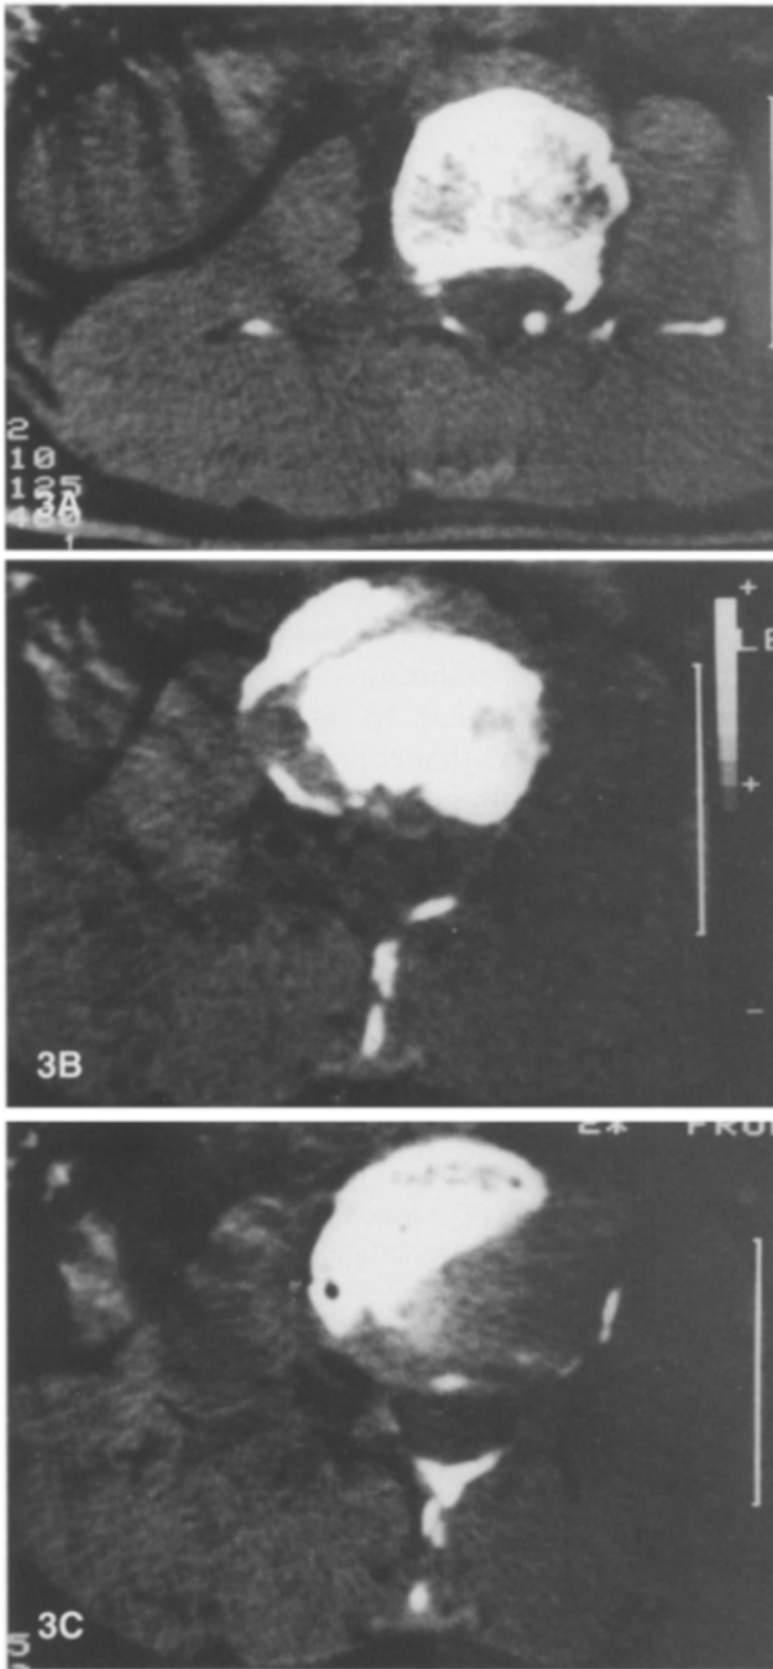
Sequential CT scans of the level L2 showing absence of the pedicles and the neural arch.
